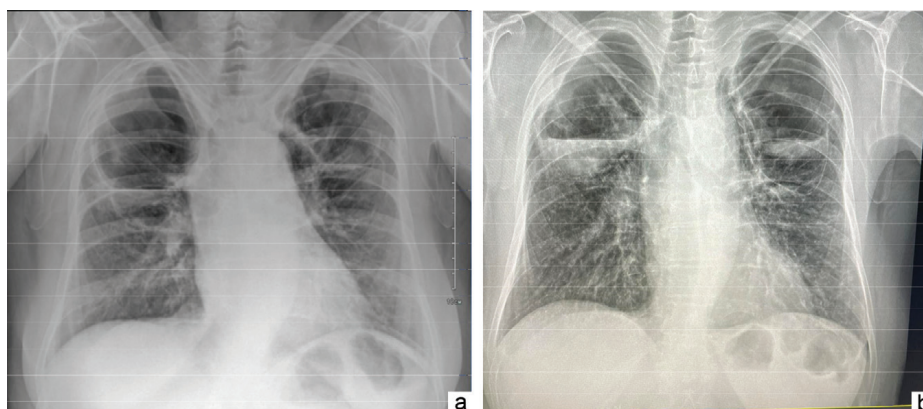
Chest X-rays of the patient on 13.07.2022 (a) and 14.03.2023 (b)
